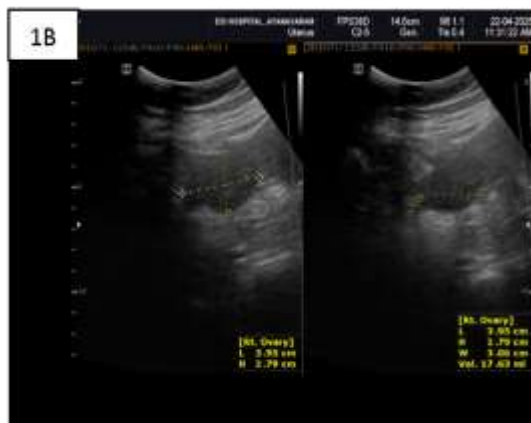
Right ovary ultrasound (Pre)Allopathic treatment
